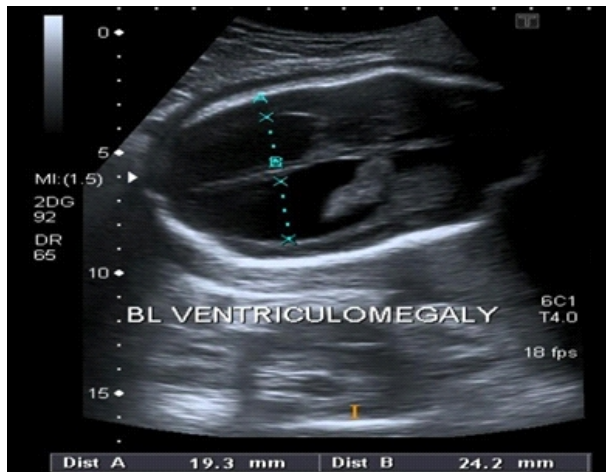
Ultrasound image of fetal head demonstrate bilateral ventriculomegaly measuring 19.3mm and 24.2mm
